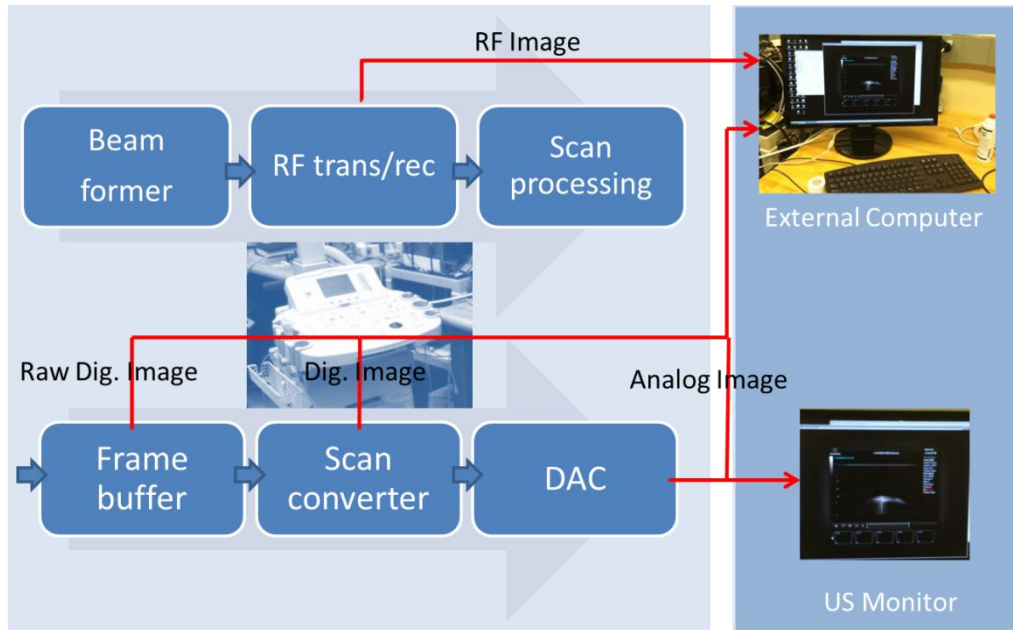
Ultrasound machine image acquisition adapted from [7]
